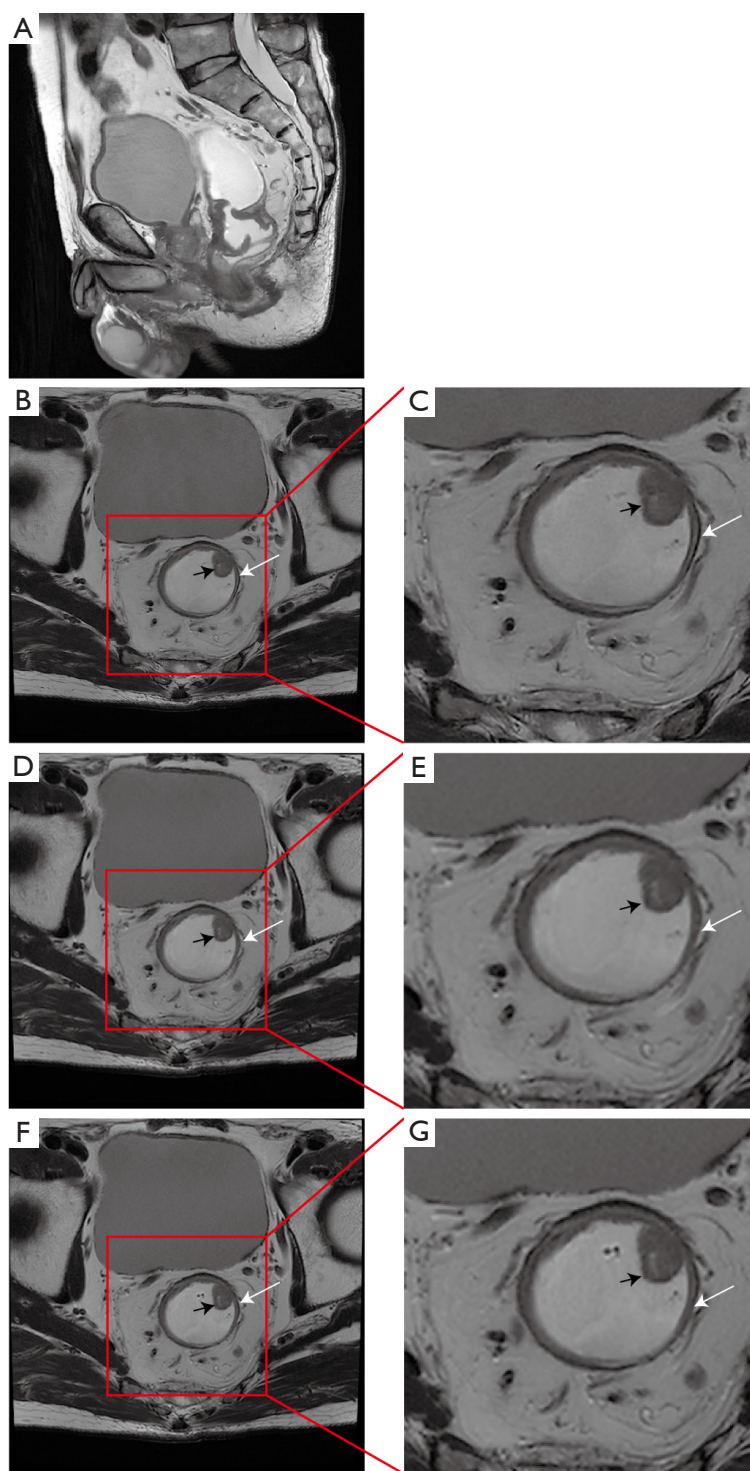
MRI of a 68-year-old male patient with pathologically diagnosed T3 rectal cancer. (A) The sagittal image; (B,C) the images of ACS-T2WI; (D,E) the images of CS-T2WI; (F,G) the images of PI-T2WI. Where (B,D,F) are the original images and (C,E,G) are the magnified images, the magnification is 2.2. The black arrows represent rectal cancer lesions, the white arrows represent the rectal wall and the selected part in the red box is the enlarged part. The visualization of intestinal wall on ACS-T2WI images are better than that on CS-T2WI and PI-T2WI images. MRI, magnetic resonance imaging; T2WI, T2-weighted imaging; ACS, artificial intelligence-assisted compressed sensing; CS, compressed sensing; PI, parallel imaging.
